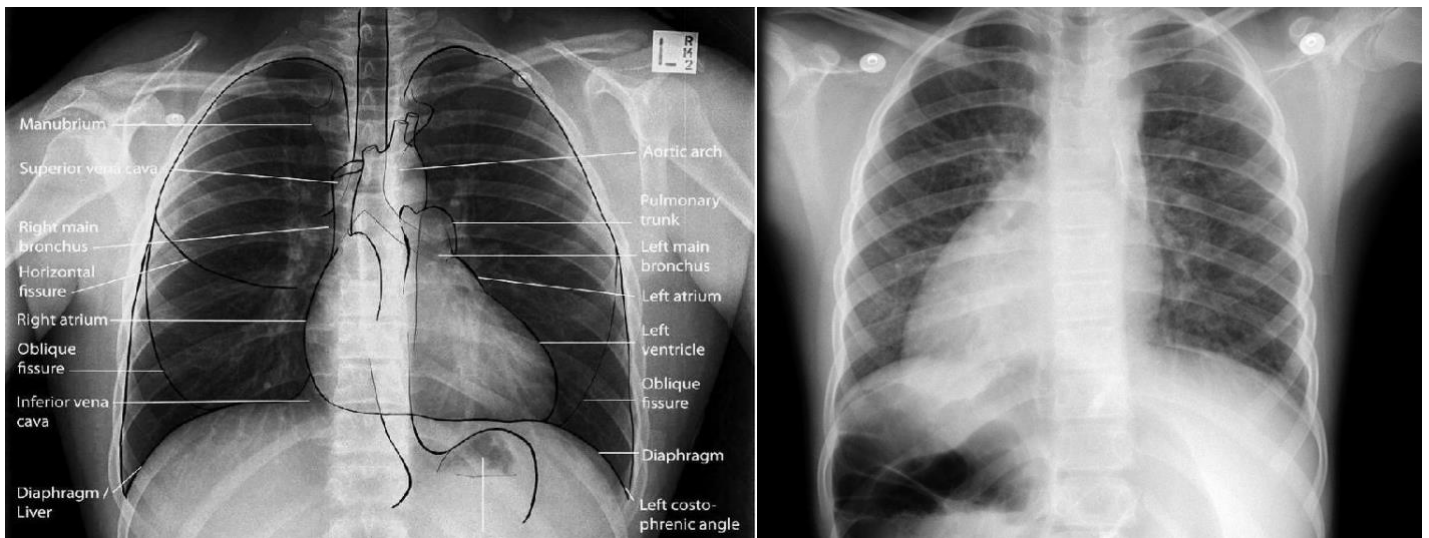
Anterior-posterior chest x-rays showing situs solitus (left) and situs inversus (right), adapted from^{99,121} Notable in the situs inversus x-ray demonstrating dextrocardia with the gastric bubble in the stomach underneath, whilst the opacity on the left hand side is the liver
